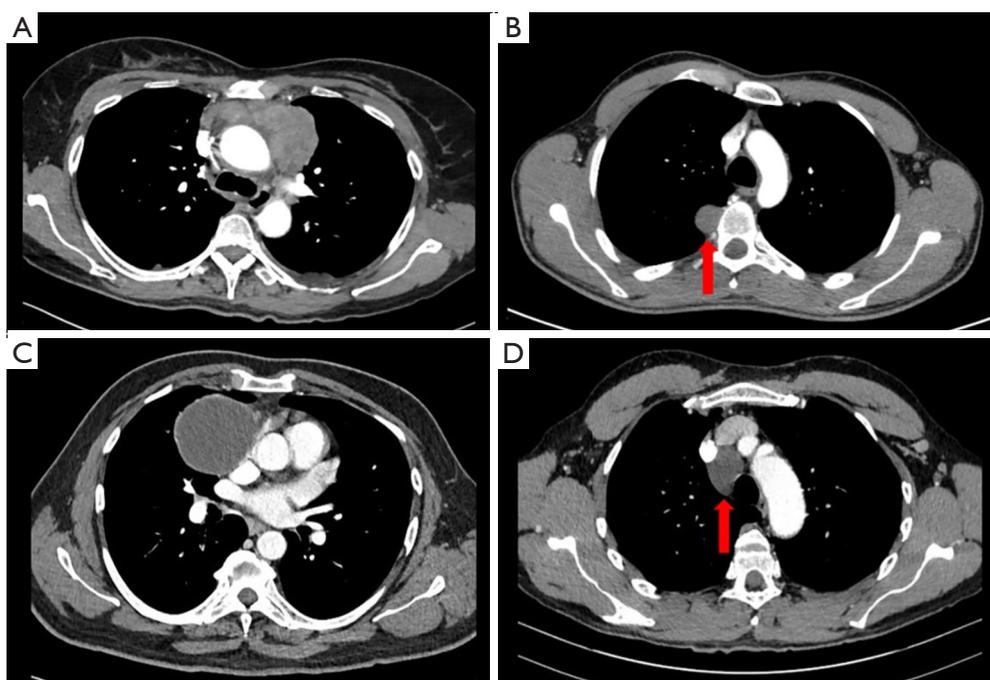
Pathologies of the mediastinum. (A) Thoracic CT showing a thymoma type B3 in the anterior mediastinal compartment, (B) CT showing a neurogenic tumor in the posterior mediastinum (arrow), (C) CT-scan showing a pericardial cyst in the antero-medial compartment of the mediastinum as well as (D) showing at CT-scan with a bronchogenic cyst (arrow) in the middle compartment of the mediastinum. CT, computed tomography.
